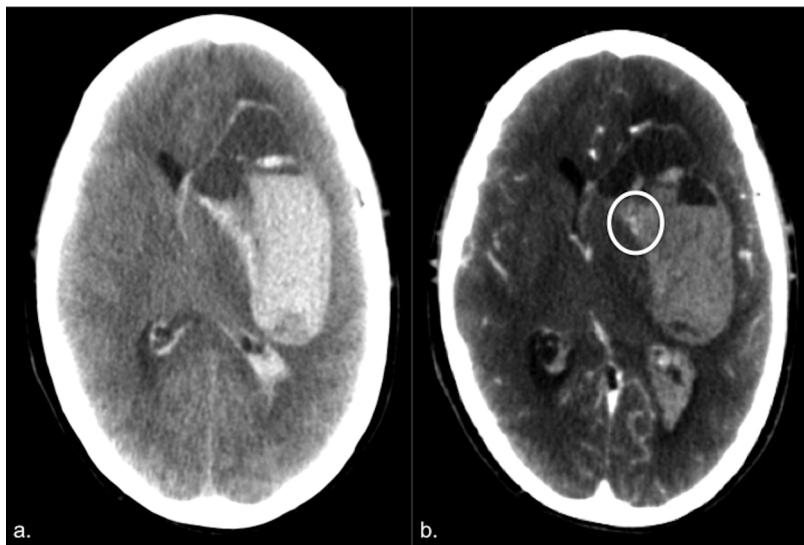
Intraparenchymal haematoma with active bleeding. A 41-year-old woman on the third day of the postpartum period, who developed headache and right hemiparesis. A CT scan of the head without intravenous contrast (a) identifies a large left-hemisphere intraparenchymal haematoma. Following administration of contrast, extravasation of contrast was seen in the sinus of the haematoma (b, circle) as a sign of active bleeding.
